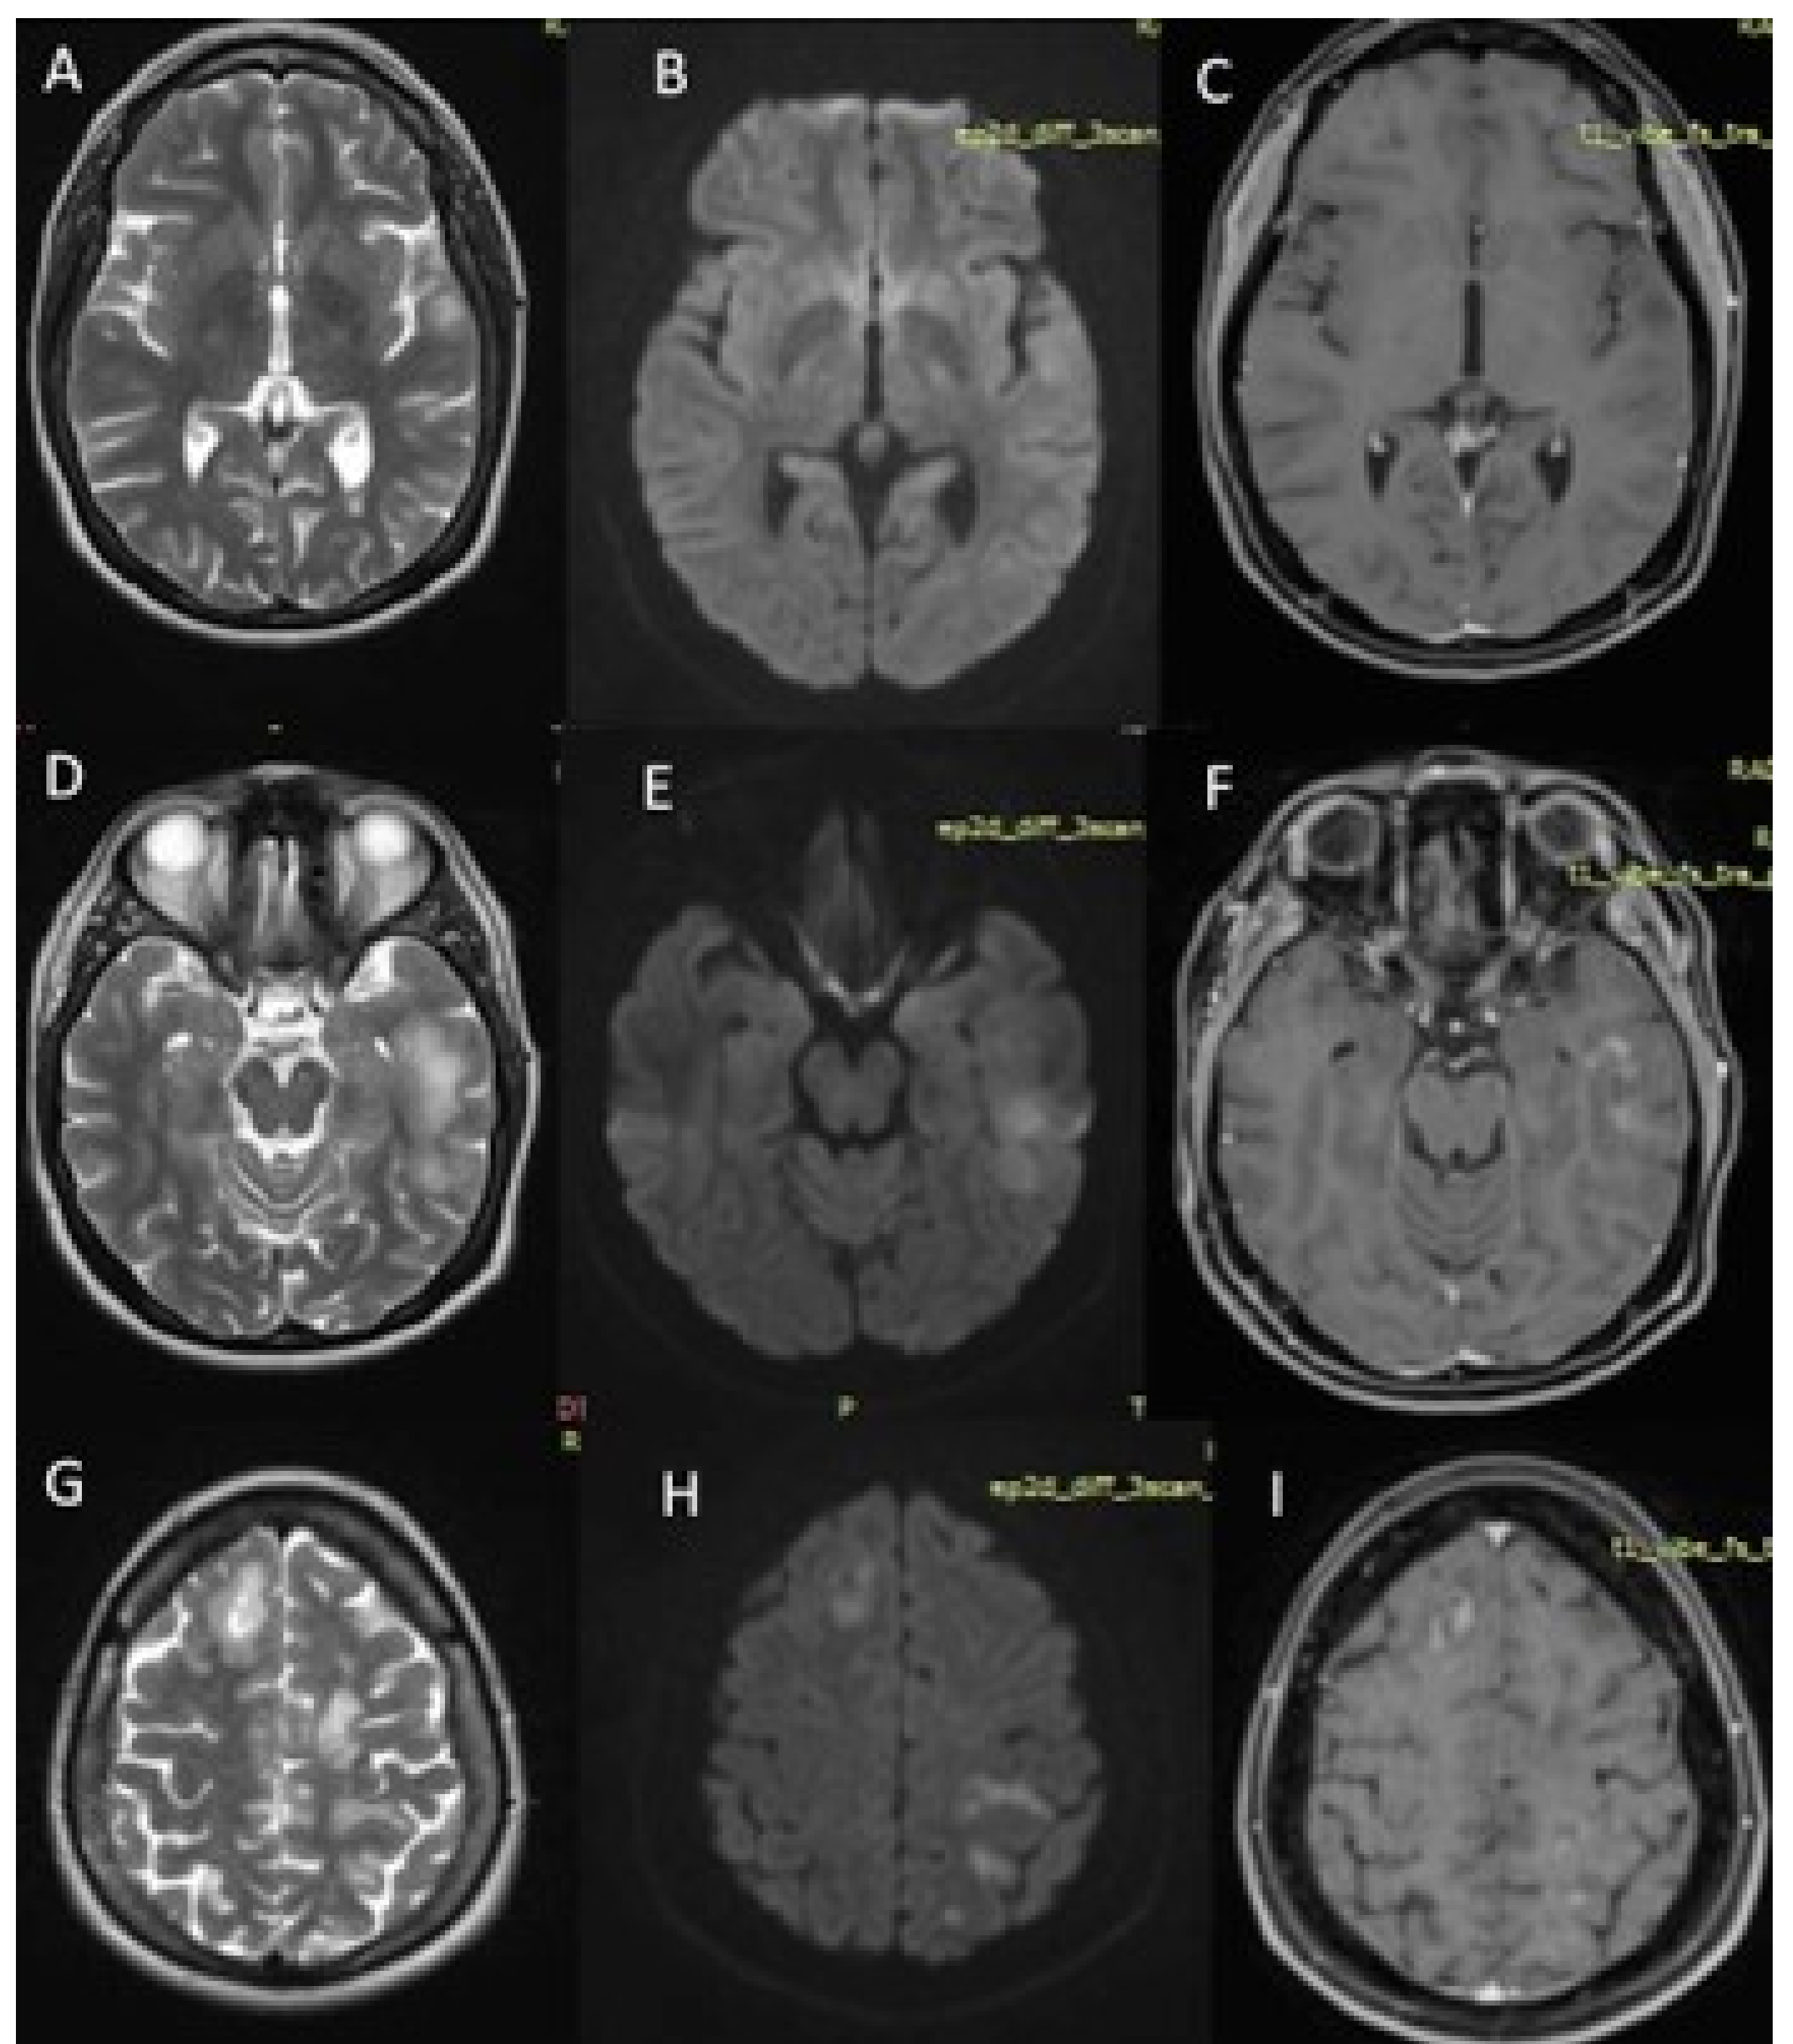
every line show axial T2W, axial DWI and axial T1 W post GD.
